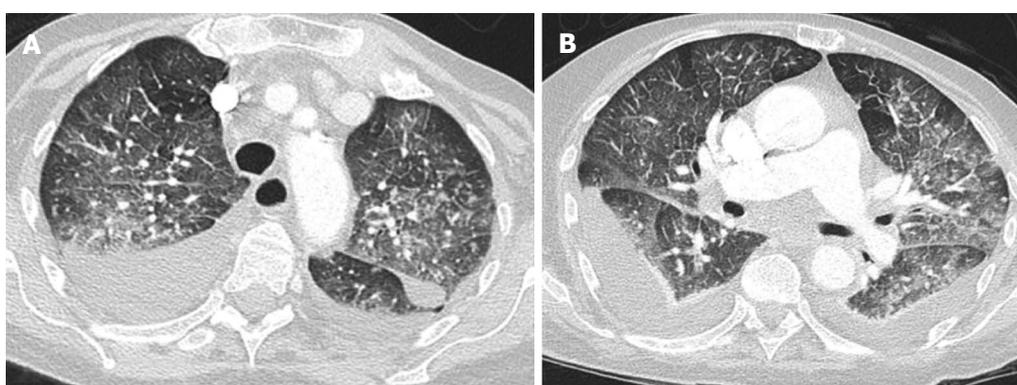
Computed tomography scan through aortic arch and pulmonary arteries planes shows ground-glass opacity with geographic distribution and partial sparing of the lung periphery. Thickening of interlobular septa and sub-pleural edema and bilateral pleural effusion with passive atelectasis of lower lobes is also present.
